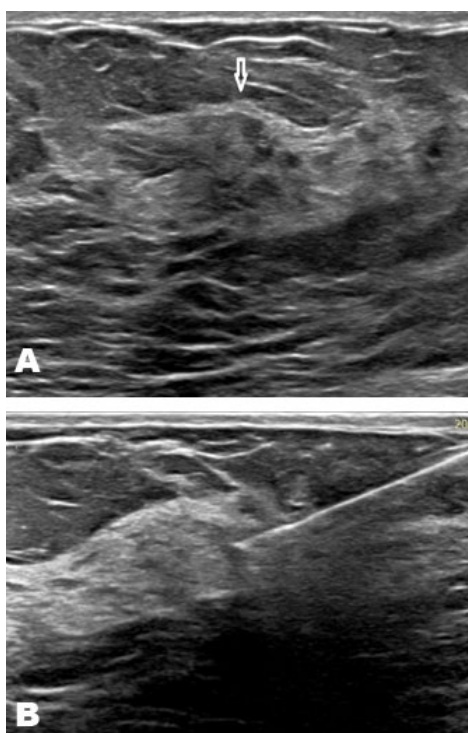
Breast ultrasound (A) showing a hypoechoic mass with indistinct contours of the left breast (arrow) is corresponding to the non-mass enhancement found at the breast MRI. (B) Left breast microbiopsy.
